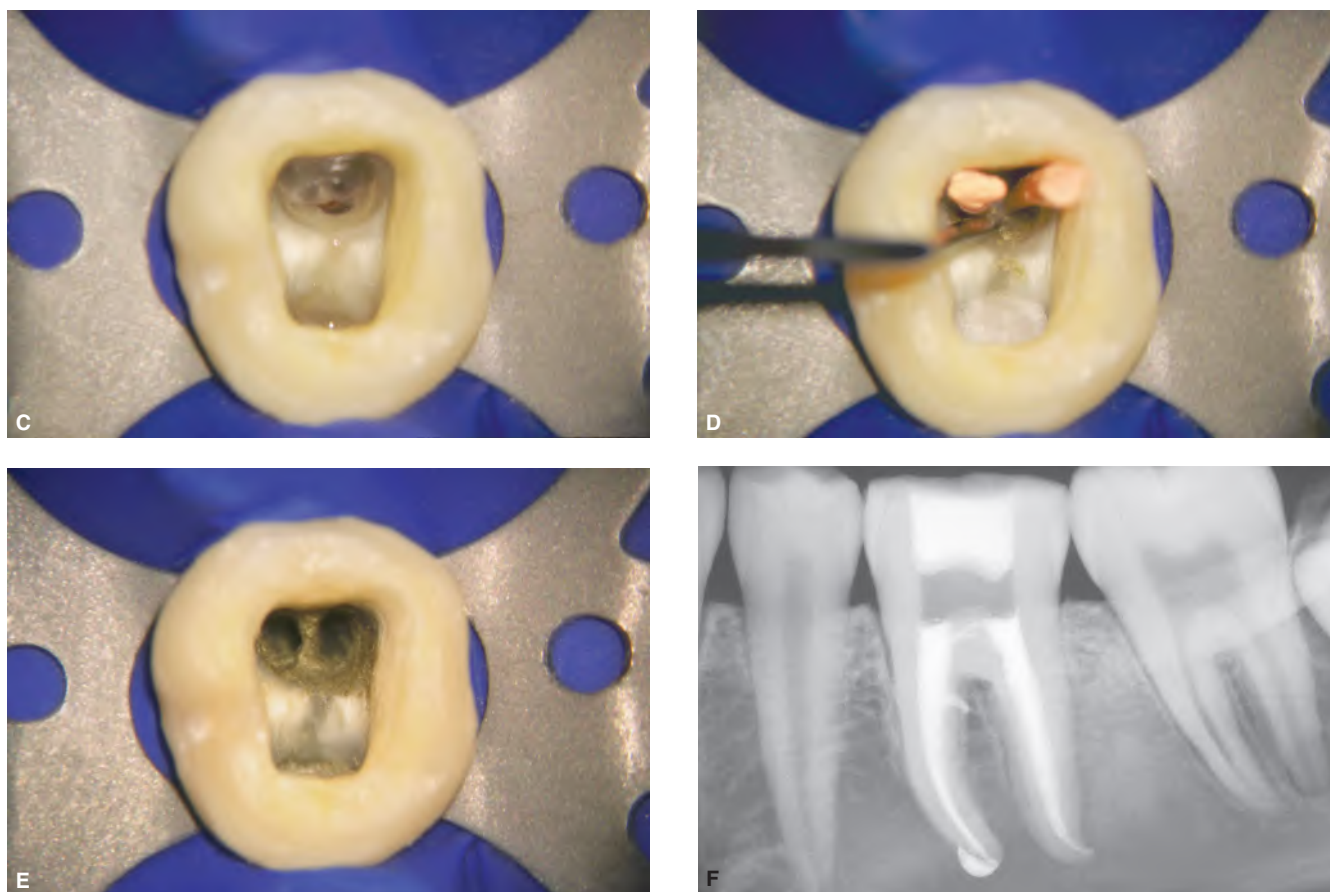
A. Preoperative radiograph of an endodontically involved mandibular left first molar. Note the previously over-enlarged mesial root. B. A photograph taken upon re-entry showing significant bleeding emanating from the mesial root. C. Photograph demonstrating hemostasis and the position of the strip perforation. D. Gutta-percha cones in the MB/ML canal systems to prevent their blockage. MTA is being vibrated into the perforation defect. E. At the subsequent visit, the gutta-percha cones are removed, the perforation repaired and the canals ready to pack. F. Postoperative radiograph showing the provisionalized tooth, four canal systems packed and the apical one-third anatomy.
